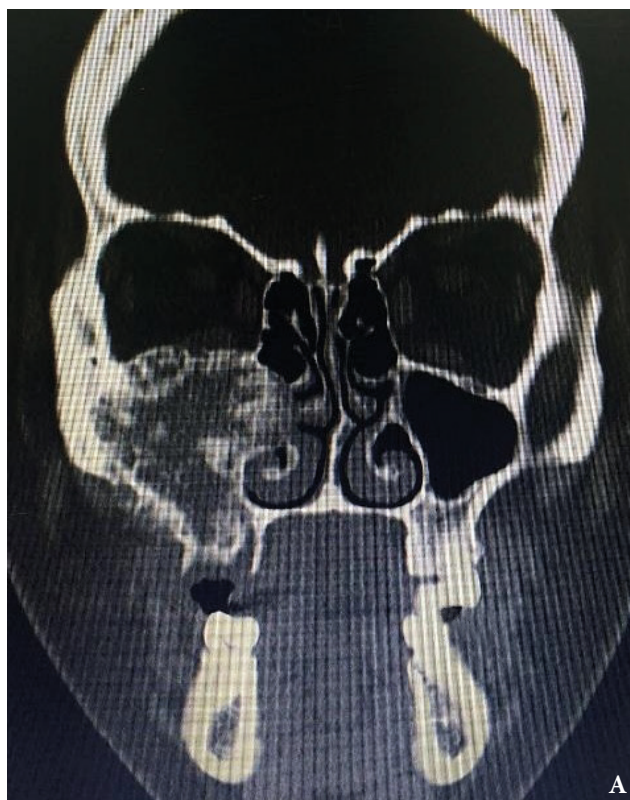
Preoperative diagnostic images: Coronal CT scan (A) and 3-dimensional reconstruction (B, C) shows orbital and maxillary tumor extension (*arrows*). Notes a medial-superior displacement of the right infraorbital foramen (*arrowheads*).
